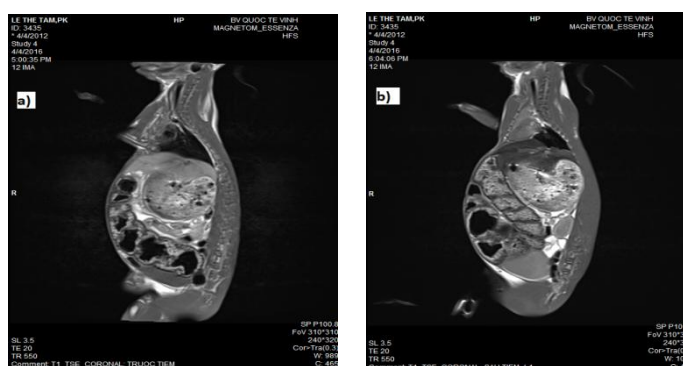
T1-weighted MR images acquired before (a) and after the injection of Fe₃O₄@PMAO (b).
